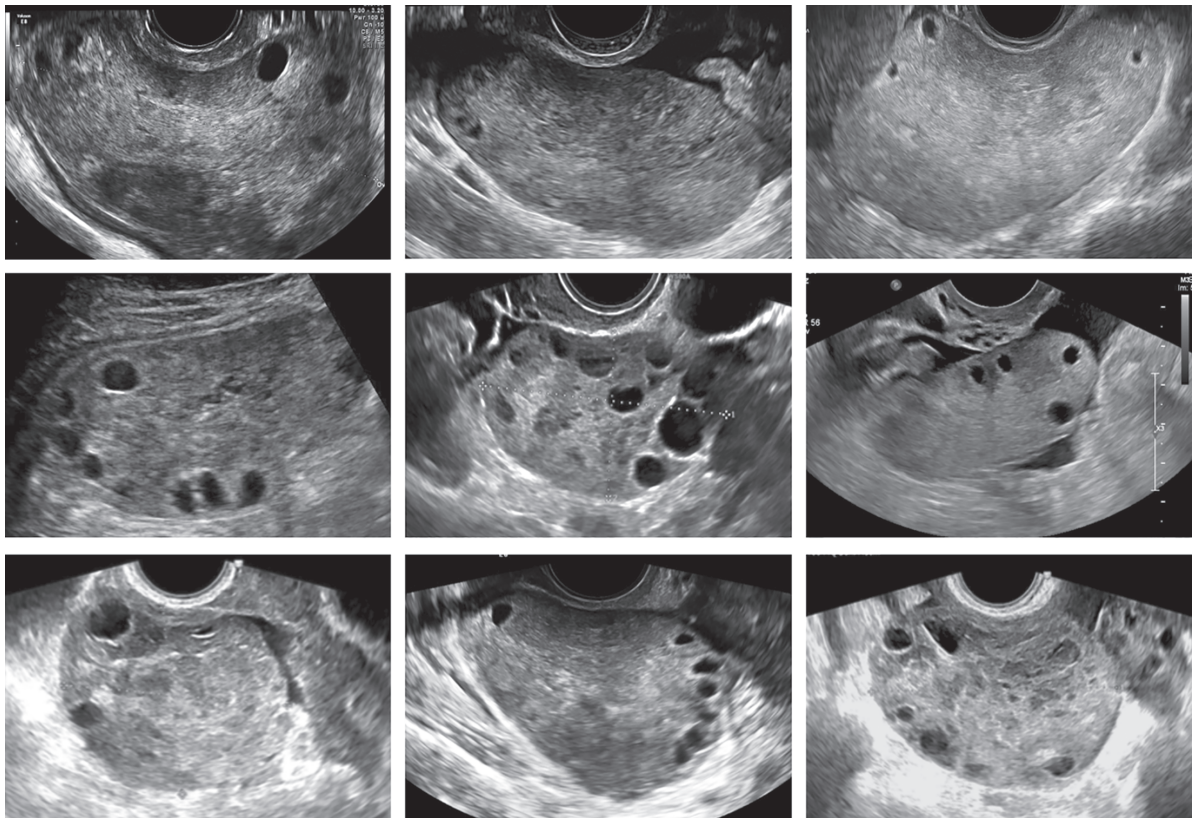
Ultrasound images of twisted adnexa, showing ovarian stromal edema with or without peripherally displaced antral follicles.
